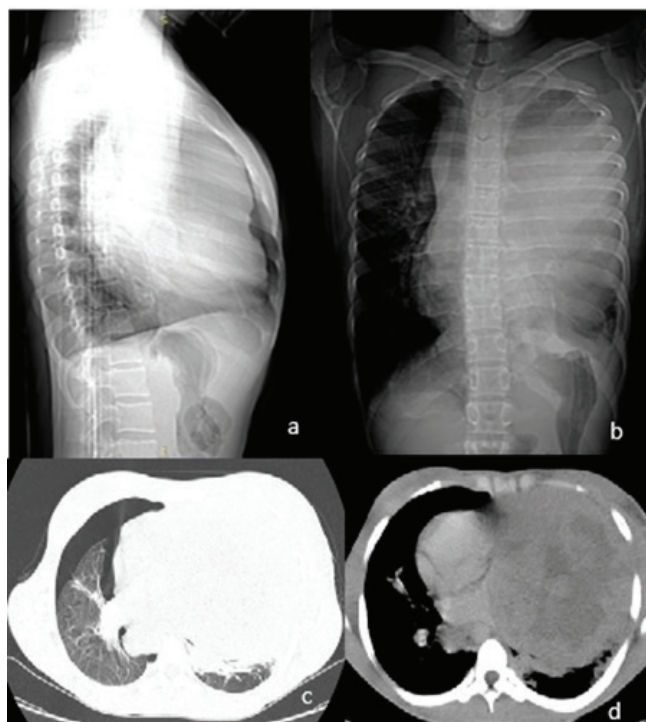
Chest CT scan showing a huge mixed-density anterior mediastinal mass measuring 17.3 x 16.4 x 12.6 cm with irregular margins and areas of necrosis extending into the left hemithorax. The mass occupies almost the entire left hemithorax with associated compression atelectasis of the left lung. It encases the arch of the aorta, superior vena cava, main pulmonary artery, and the descending thoracic aorta. It is adherent to the left side of the pericardium, and a right-sided pneumothorax can also be seen (a-d).
